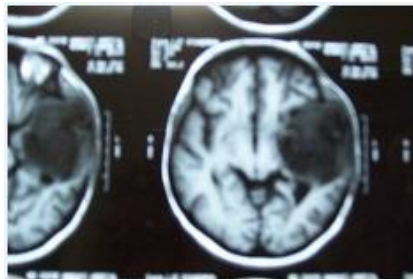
CT scan report showed a hypodense lesion non-enhancing about 8.6x6.7x5.8 cm in left temporo-parietal lobe.
